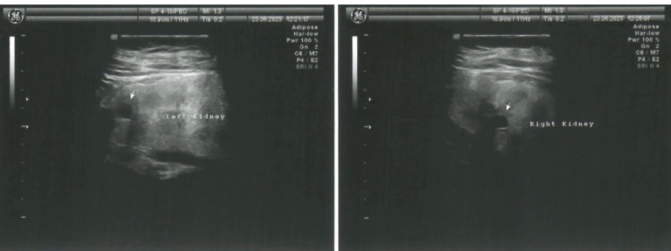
Ultrasound of the kidneys of a patient with nephronophthisis type 1.
